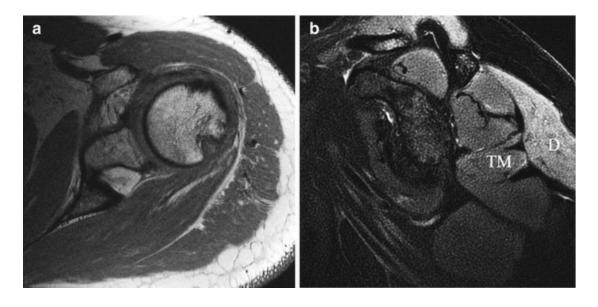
Axillary nerve trauma after an anterior glenohumeral dislocation. (a) Axial T1-weighted MRI shows a Hill-Sachs lesion and fatty degeneration of the deltoid muscle. (b) Sagittal fat-suppressed T2-weighted MRI shows mild muscle atrophy and a high signal of the teres minor (*TM*) and deltoid (*D*) muscles
